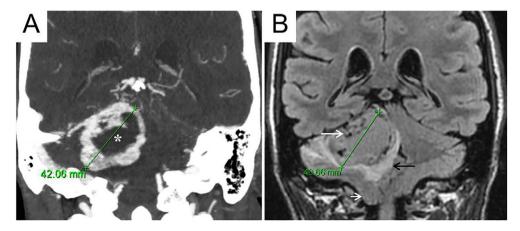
Radiological imaging of a giant CPA HB in the current patient. (A) Coronal enhanced CT scan of the right CPA tumor showing intense contrast uptake. There was a central cystic region (asterisk) surrounded by thick hypervascular parenchyma. (B) Coronal MRI using a fluid-attenuated inversion recovery sequence. Note the prominent flow voids (white arrow) that, together with the intense enhancement, raised suspicion of a HB diagnosis. The lesion exerted marked mass effect and edema on the surrounding cerebellum (black arrow) and produced tonsillar herniation (short arrow).
